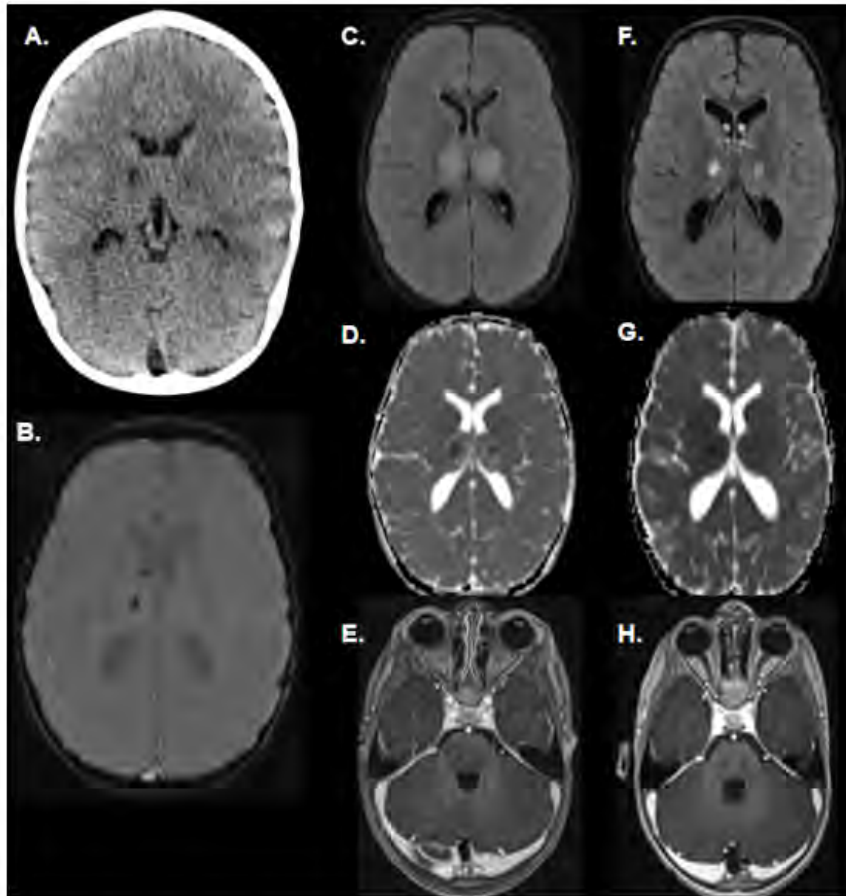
Multimodality Radiologic Assessment of Acute Necrotizing Encephalitis Pre- and Post-Treatment. Initial noncontrast CT head demonstrated nonspecific bilateral thalamic hypodensities (Figure 1A). Contrast enhanced MR Head demonstrated punctate thalamic microhemorrhage on SWI (Figure 1B), marked edema and swelling of the bilateral thalami on T2/FLAIR weighted imaging (Figure 1C) with associated areas of diffusion restriction with a layered appearance on ADC mapping (Figure 1D), and patchy peripheral enhancement of pontine cavitations (Figure 1E). Subsequent contrast-enhanced MR Head status post treatment, demonstrated decreased bilateral thalamic edema (Figure 1F) with associated decreased diffusion restriction (Figure 1G) and resolution of pontine enhancement (Figure 1H).
